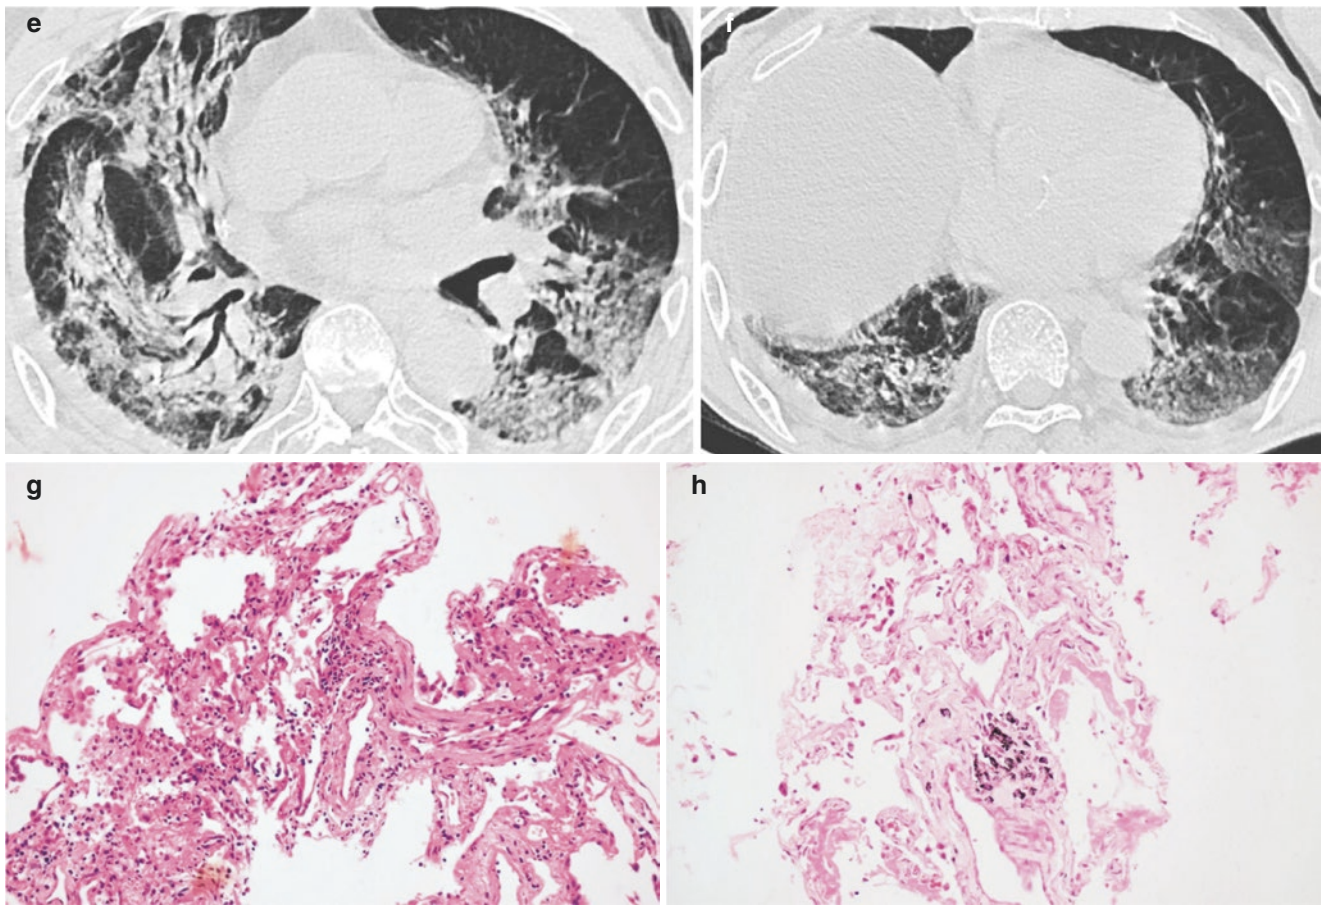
Chest CT images showed multiple ground-glass opacities in both lungs, especially in the right lung, which, with local consolidation and thickening of interlobular and intralobular septa, formed a “crazy-paving pattern” (a). There was a little pleural effusion (a–f). The pathological images showed a pink hyaline membrane attached to the alveolar
